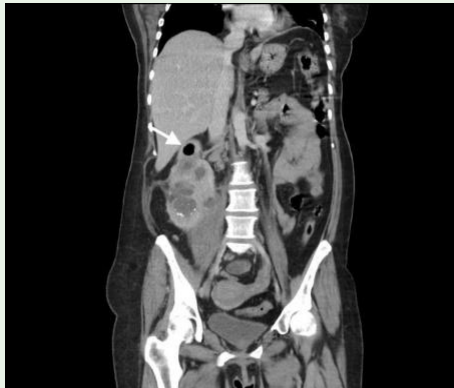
A coronal view of abdominal computed tomography shows an enlarged right-kidney and peri-renal gas (arrow).
